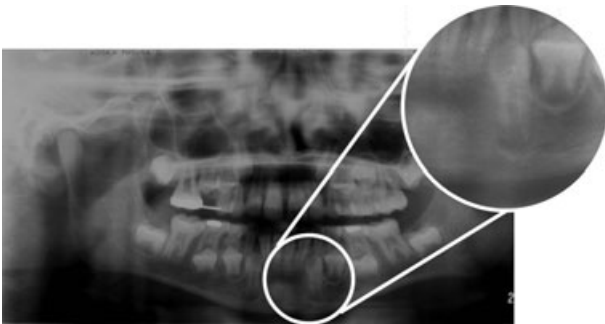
Panoramic radiograph and magnified detail. Situation 36 months after the trauma. Bony healing in formerly fractured region.
